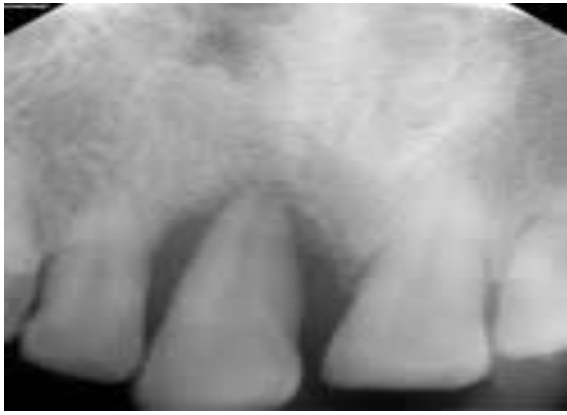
Baseline radiograph
